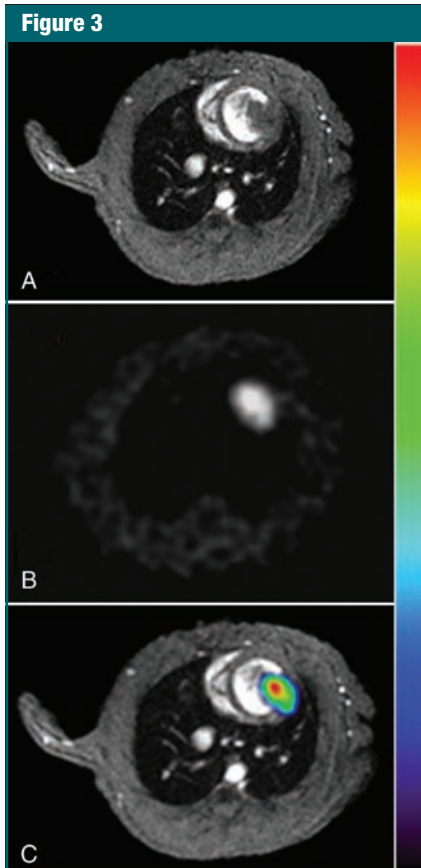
Coregistration of PET and MR images. *A*, Short-axis cardiac MR image (section 4 from multisection series) of infarcted heart 14 days after receiving 5 million double-labeled ESCs. *B*, Corresponding FHBG image. *C*, Coregistered color-scale PET images and gray-scale MR images obtained by using mutual-information-based algorithm. Figure E5 (<http://radiology.rsnajnl.org/cgi/content/full/250/3/821/DC1>) shows coregistration of multiple short-axis sections.
